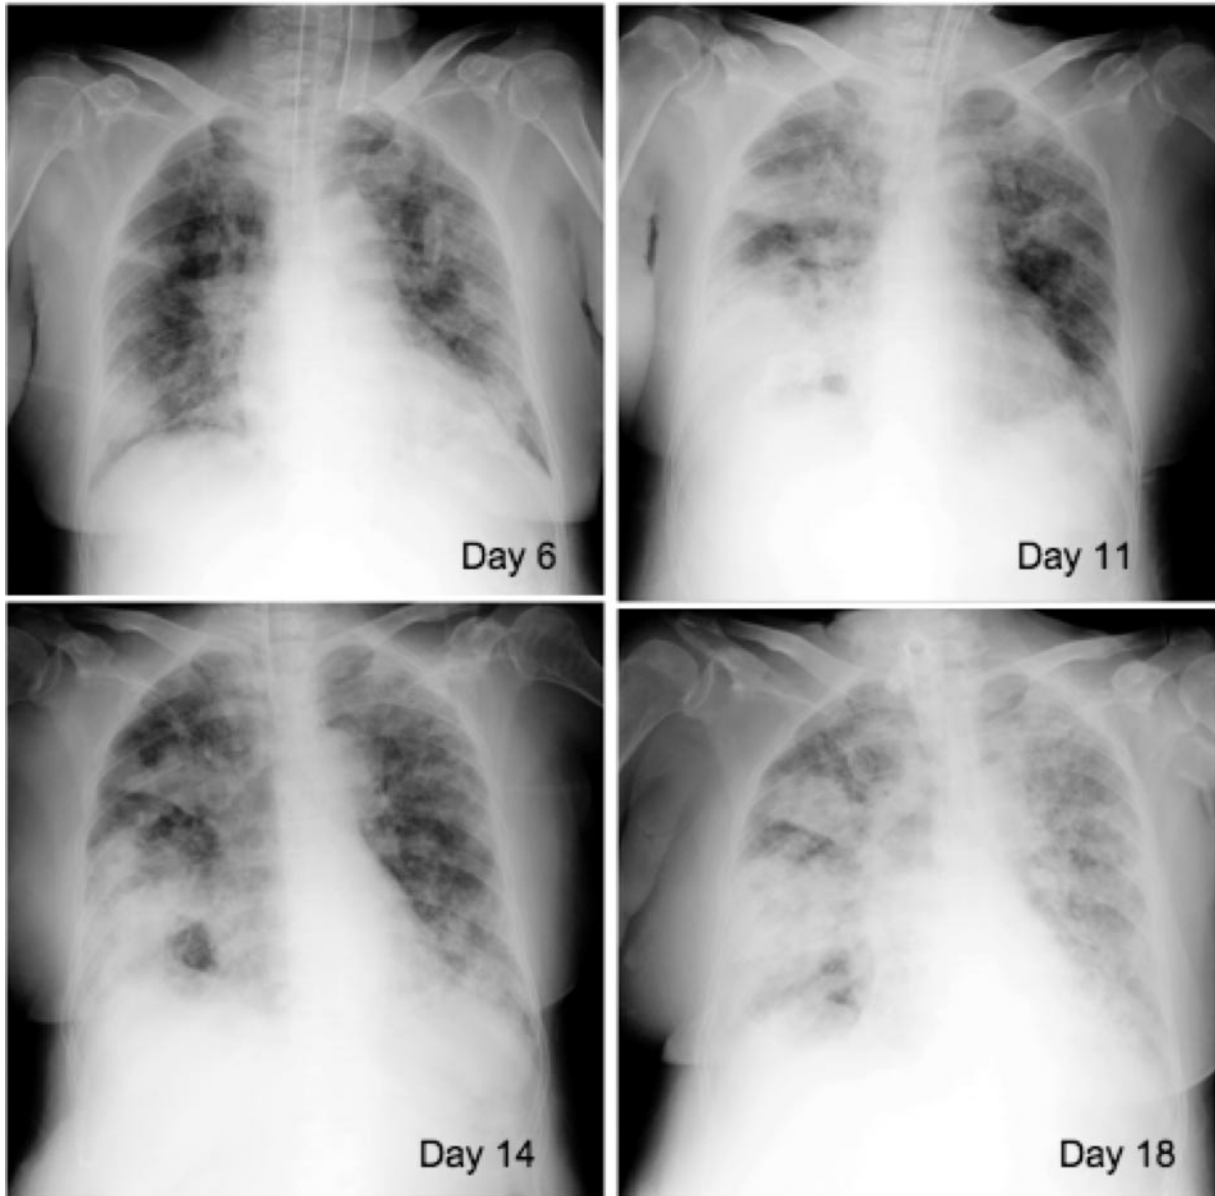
Serial chest radiograph showing a rounded opacity in the right lower zone on day 6, which gradually increased in size (day 11), with additional involvement of the right upper zone, giving an appearance of a fungus ball (day 14) in the lower zone, and finally involving the bilateral lung fields on day 18.
